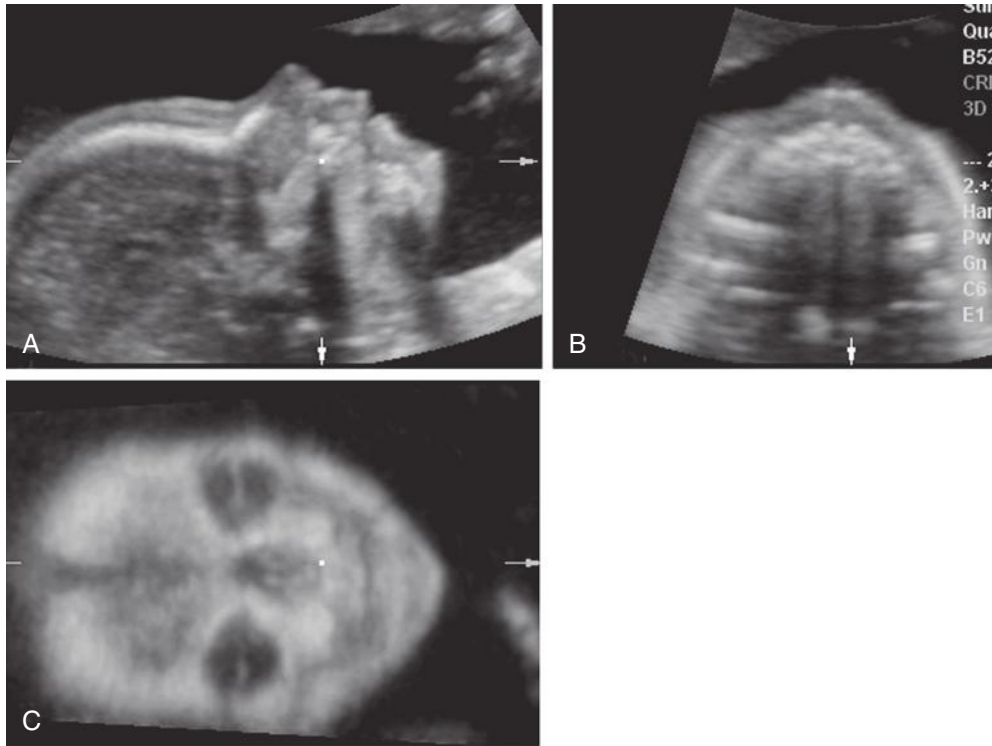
Three-dimensional ultrasound images of normal fetal face. Multiplanar display demonstrating simultaneously sagittal (A), axial (B), and coronal views (C) of the fetal face.
